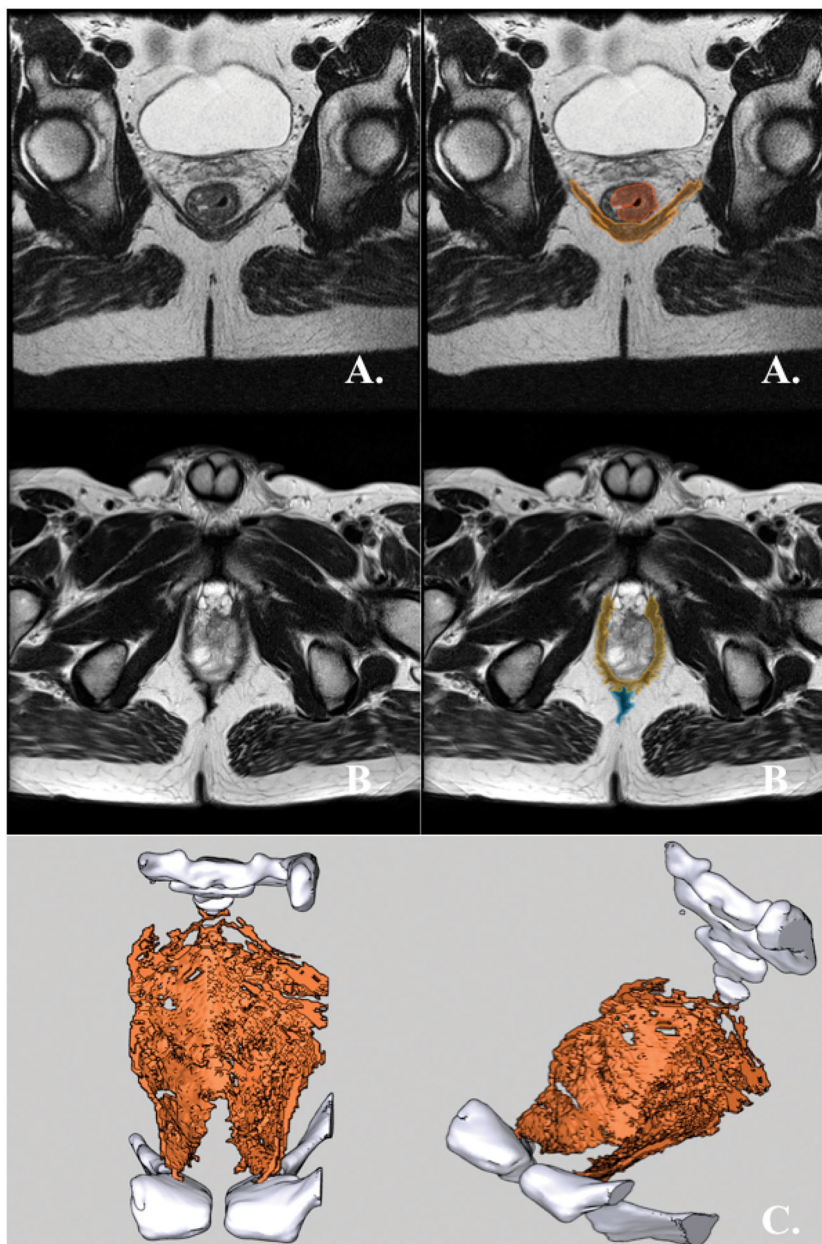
c-APE. (A) Preoperative axial T2-weighted MRI of a rectal cancer patient with an mrT3-tumor with invasive growth between 2 and 4 o'clock. RPD is hatched in orange. The tumor is hatched in red. (B) Postoperative axial T2-weighted MRI of the same patient after cAPE. RPD is hatched in orange. Cicatrice is hatched in blue. (C) The RPD of the same patient, 3D-rendered and shown in superior and antero-lateral superior views. The rendering is made from the above postoperative MRI. The bony pelvis is rendered in white, while RPD is rendered in orange. No bio-mesh was used for supporting the closure of the defect in the pelvic diaphragm.
